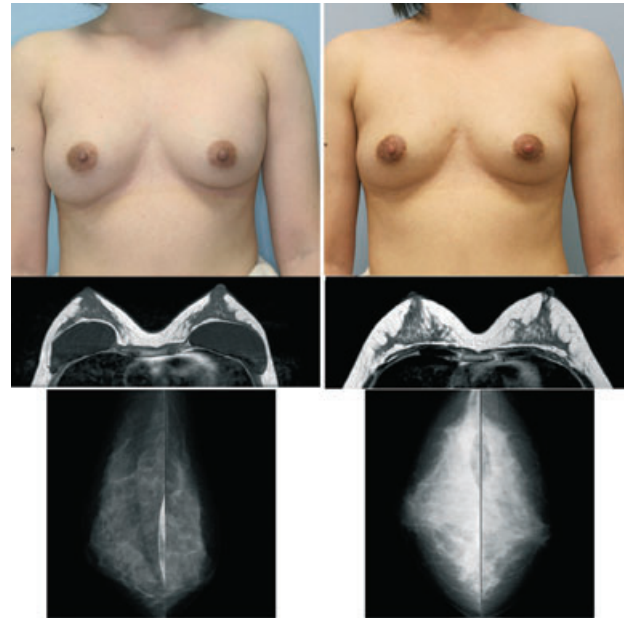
Clinical and radiological views of Case 4. Preoperative (left panel) and postoperative views at 12 months (right panel). Clinical views showed capsular contractures and downward displacement of the right implant before surgery (top, left), while the breasts were symmetrical and had a natural appearance at 12 months (top, right). The T1-weighted MRI (middle, left, and right) revealed that the fatty layers around the mammary glands were much thicker at 12 months than they were previously. Mammograms showed no calcifications or other abnormal signs in either breast before or at 12 months (bottom, left, and right). Augmented breast mounds maintained sufficient breast volume even after implant removal; they were naturally soft without any subcutaneous indurations or visible injection scars at 18 months (see also Video S4).
